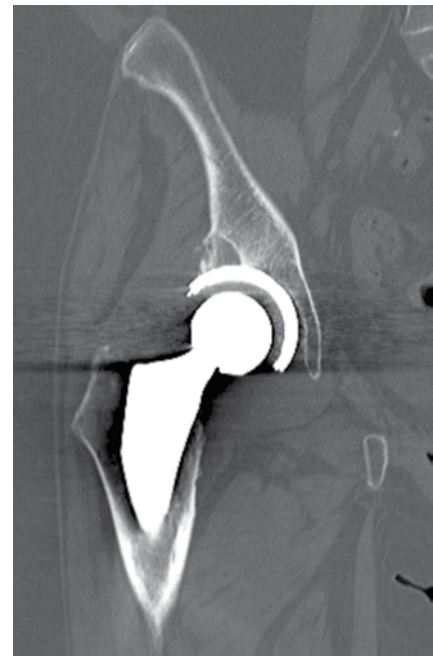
Computed tomography scan of the right hip showing a fairly localized area of bone destruction with some surrounding sclerosis. Neoplasm (particularly metastatic disease) was included in the differential diagnosis.
